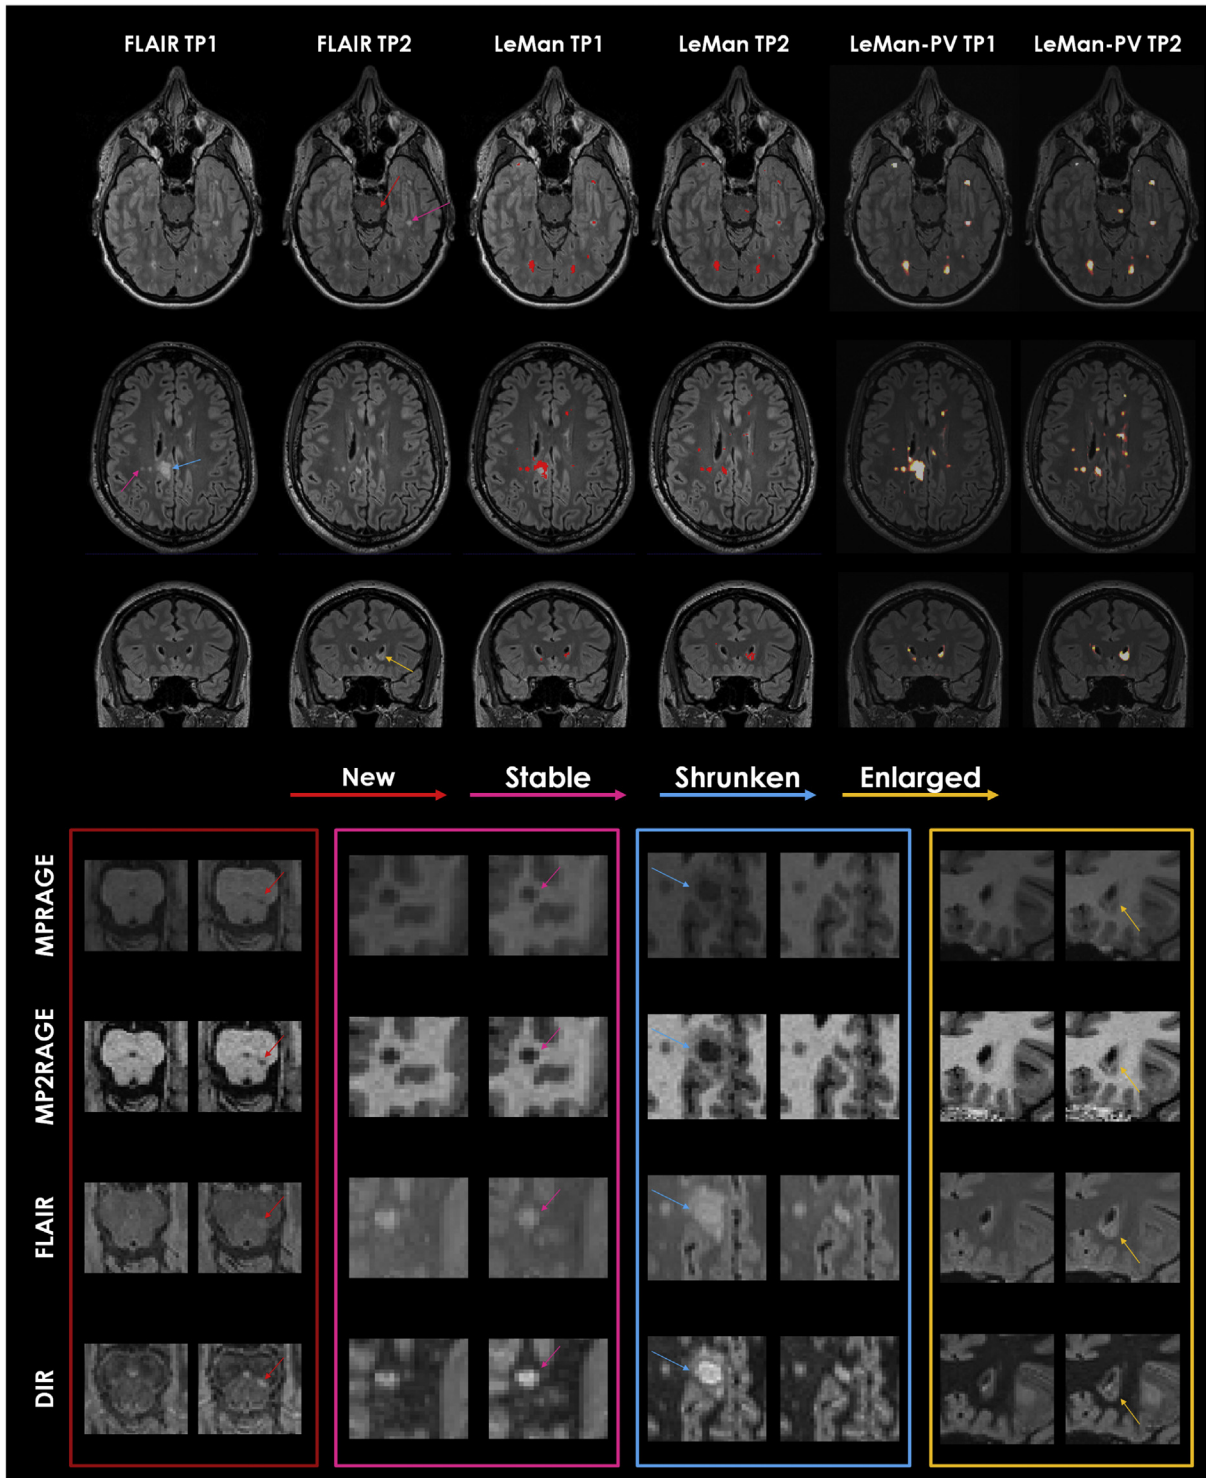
From top to bottom: Axial FLAIR image in a 34-year-old woman; Axial FLAIR image in a 32-year-old man; Coronal FLAIR image in a 39-year-old woman. All cases are relapsing-remitting MS. FLAIR images are shown for the registered time point 1 (TP1) and the respective time point 2 (TP2). Results from algorithm before (LeMan) and after (LeMan-PV) applying the partial volume model using the conventional protocol are shown in the 3rd-4th and 5th-6th columns, respectively. The output of Leman is a binary mask and the output of LeMan-PV is a concentration map. Examples of new, stable, shrunken, and enlarged WM lesions are indicated with red, pink, blue, and yellow arrows, respectively. Patches of the zoomed area of the different lesion categories in each image contrast (MPRAGE, MP2RAGE, FLAIR, and DIR) are shown at the bottom. (For interpretation of the references to color in this figure legend, the reader is referred to the web version of this article.)
